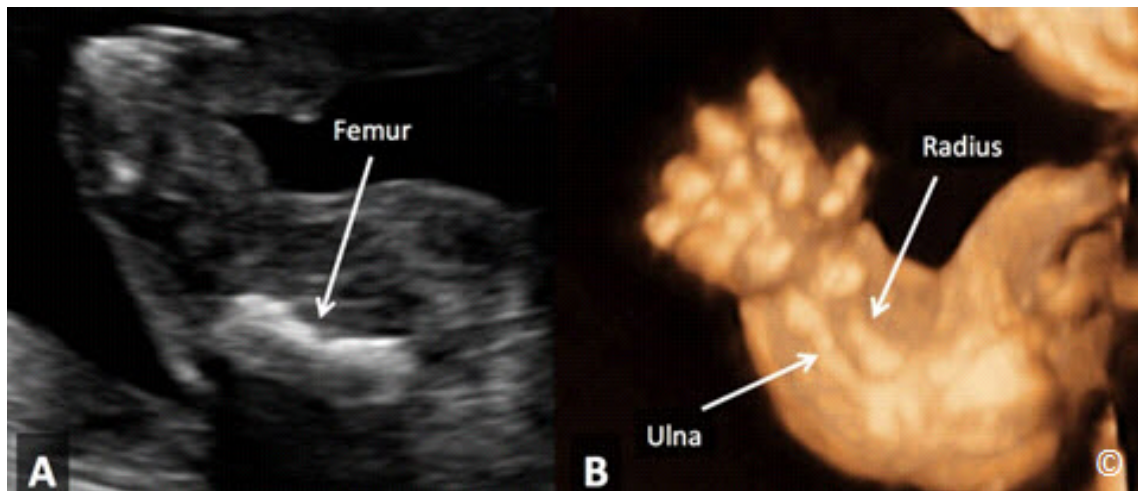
Longitudinal view of the femur in 2D mode (A), and the upper extremity in 3D ultrasound (B) of a fetus with lethal skeletal dysplasia. Note the severe shortening and bowing of the long bones.
